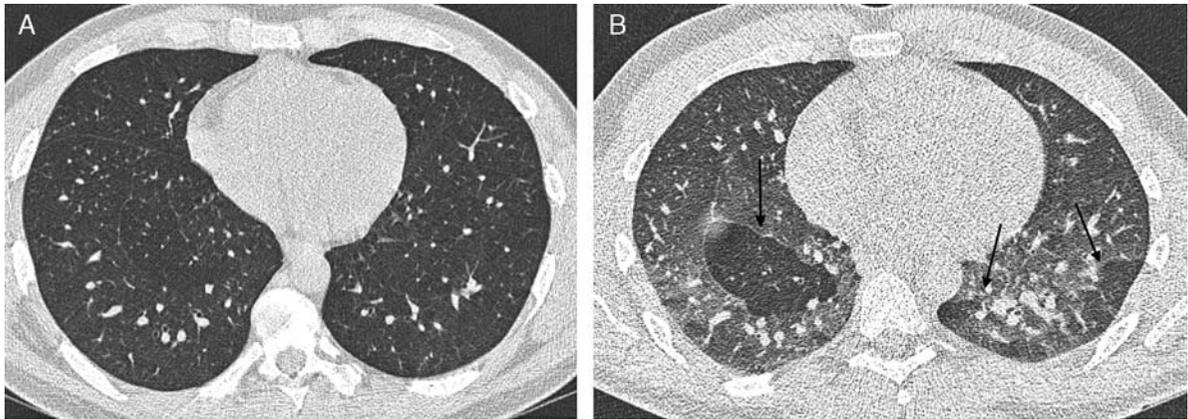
Imaging results of a 36-year-old man with WTC-related sarcoidosis. A, Inspiratory HRCT image through the bases demonstrating uniform lung attenuation. B, Expiratory HRCT image at the same level, demonstrating mosaic attenuation in the lower lobes. Opacity within the normal lung has increased on expiration, whereas geographic areas of low attenuation (black arrows) reflect regional air-trapping. PFTs, however, showed no evidence for OAD.
